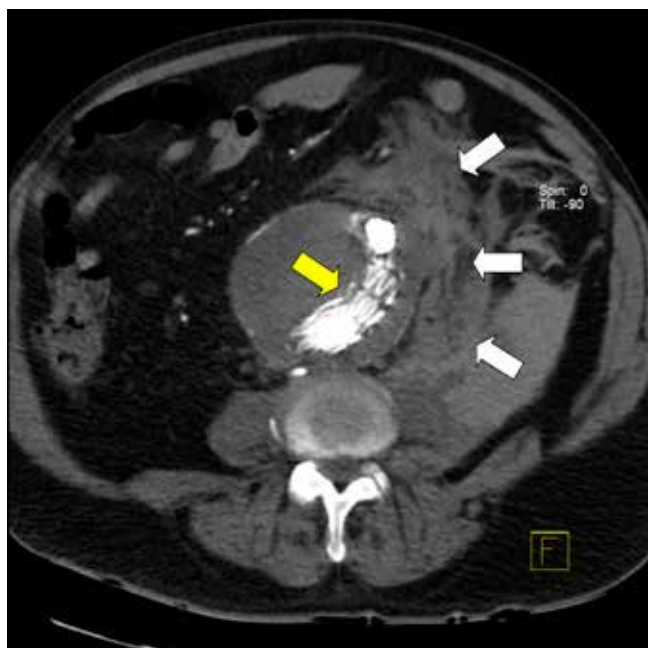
Post-EVAR CT image of a patient with a ruptured AAA.
